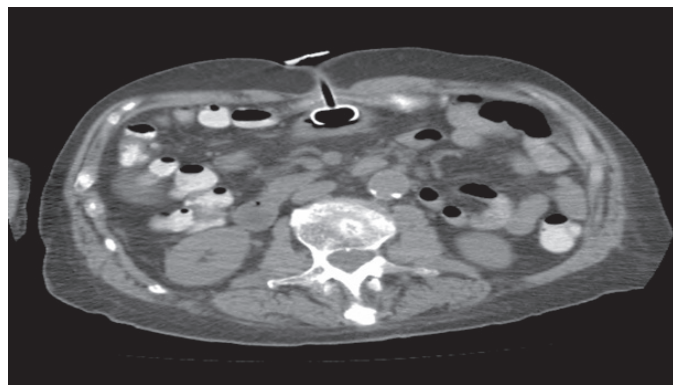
Computed tomography scan of abdomen revealing gastrocolocutaneous fistula.
